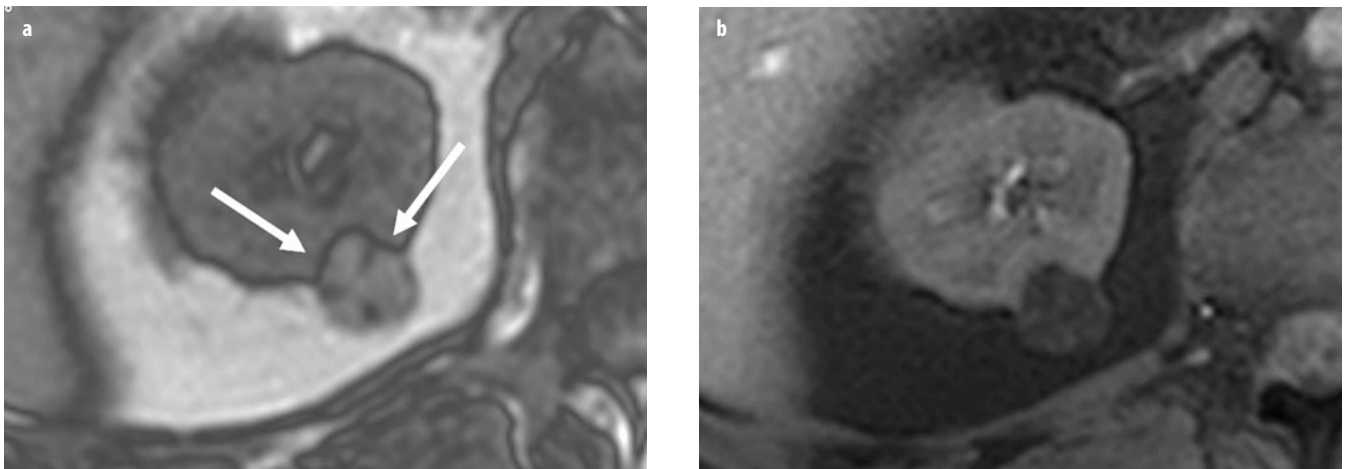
a, b. a Axial opposed-phase T1-weighted magnetic resonance image (MRI) shows hyperintense mass in the upper pole of the left kidney. India ink artifact (*arrows*) is present at the interface of renal mass and kidney, which is diagnostic of angiomyolipomas (AML). b The mass loses signal on fat-suppression images, confirming the diagnosis of AML
